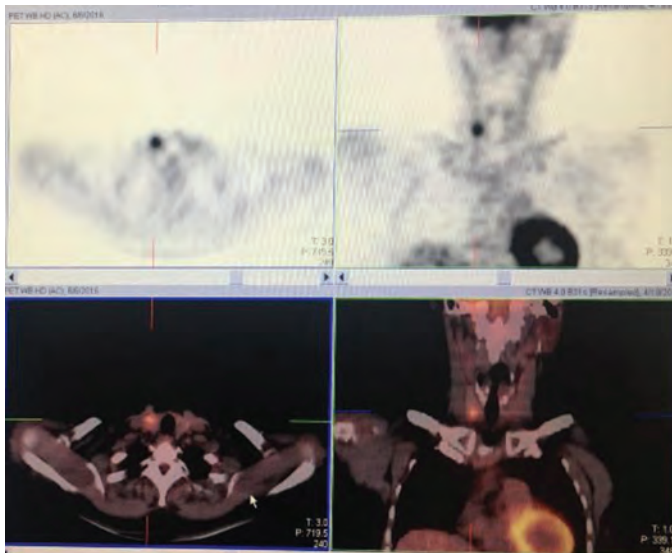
Malignant thyroid nodule that shows focal FDG uptake. A 46-year-old female patient underwent an ¹⁸F-FDG PET/CT study for the evaluation of cancer of unknown primary origin. Axial PET and fusion images (left column) and coronal PET and fusion images (right column) show focal FDG uptake in the right lobe of the thyroid gland. (SUV_{max}: 7.8). Ultrasonography showed an 11 mm nodule corresponding to the focal uptake. FNAB from the nodule revealed atypia of unknown significance. Subsequently, the patient underwent a total thyroidectomy, and the pathology results revealed papillary thyroid carcinoma
